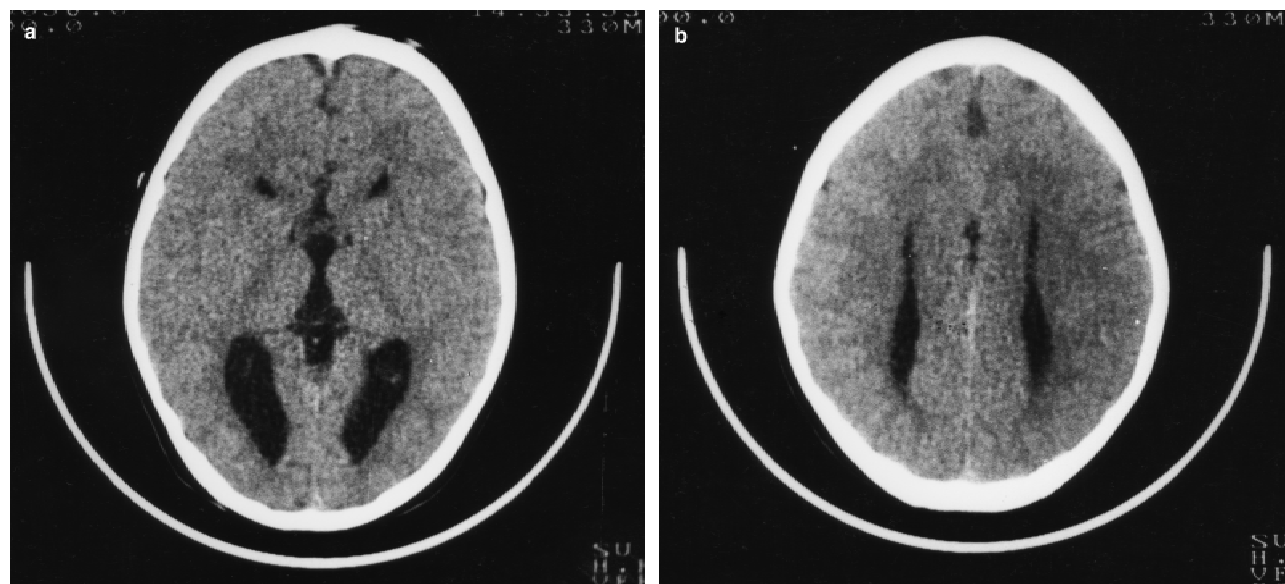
CT scans showing ACC. a: Axial slice of a CT. A cystic dilation dorsal to the third ventricle as well as a subtle dilation of lateral ventricles can be seen. b: Axial slice of a CT on an upper plane. Lateral ventricles adopt a parallel conformation.
